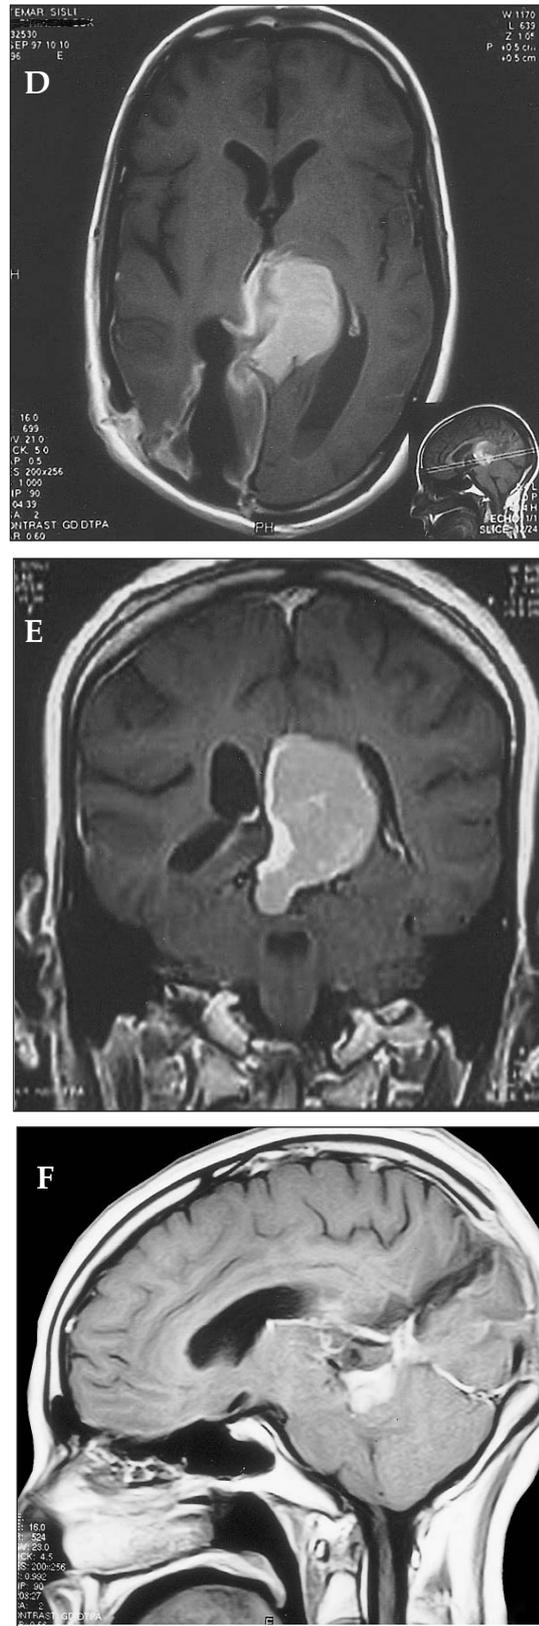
2E, 2F: Case 2: After the operation, post-gadolinium axial, coronal and sagittal plane T1-weighted images show residual mass in the pineal region and some postoperative changes in the surrounding parenchyma.
